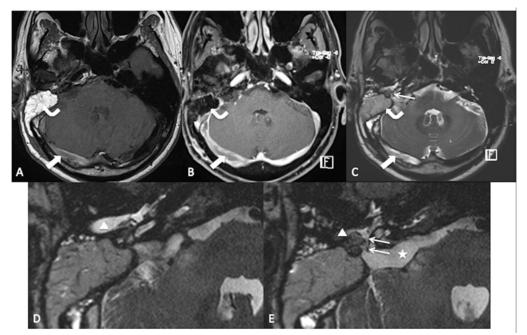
MRI of the brain on T1W (A), T1W fat-saturated with contrast (B), T2W (C) and magnified view of the right CPA on CISS3D (D) & (E). The mastoid cavity is packed with fat (curved block arrow). On the CISS3D, the right external auditory canal and middle ear cavity are fluid-filled (triangle) with fluid tracking posteriorly communicating with the CPA cistern (star) through a small tract (arrow). The right transverse sinus has lost its normal flow void on T2W, with a hyperintense signal on T1W and a filling defect on T1W post contrast consistent with dural sinus thrombosis (block arrow).
